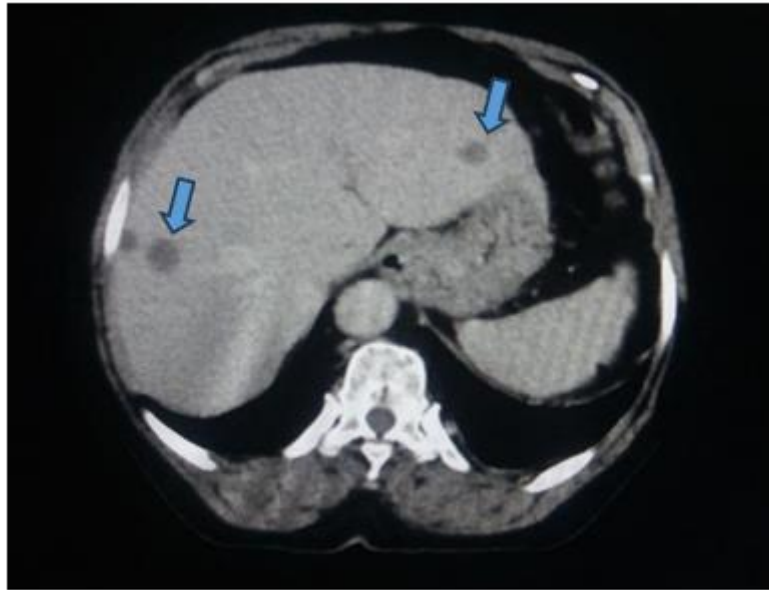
Abdominal CT scan in axial section without injection of contrast product and (c) after injection of contrast product in the portal phase, highlights hepatic nodules in a 50-year-old woman
